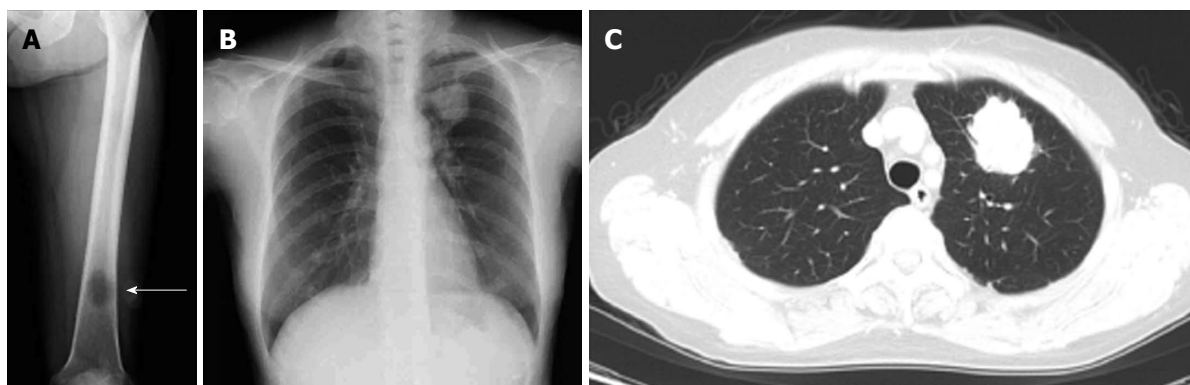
Images of the patient on admission. A: An X-ray of the left femur showed an osteolytic change (arrow); B: Chest X-ray showed a tumor shadow; C: Chest computed tomography showed a 4-cm tumor, which was considered to be the primary lesion.
